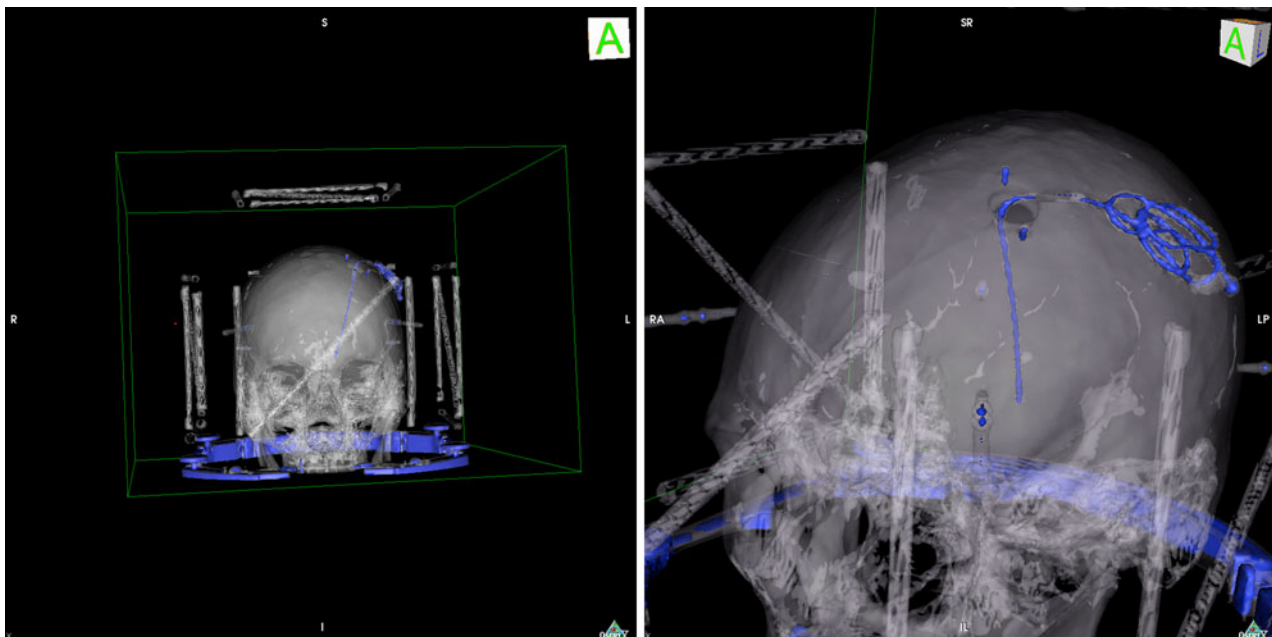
Visualization of electrode segmentation of electrode performed from stereotactic CT image following pneumocephalus resolution.
